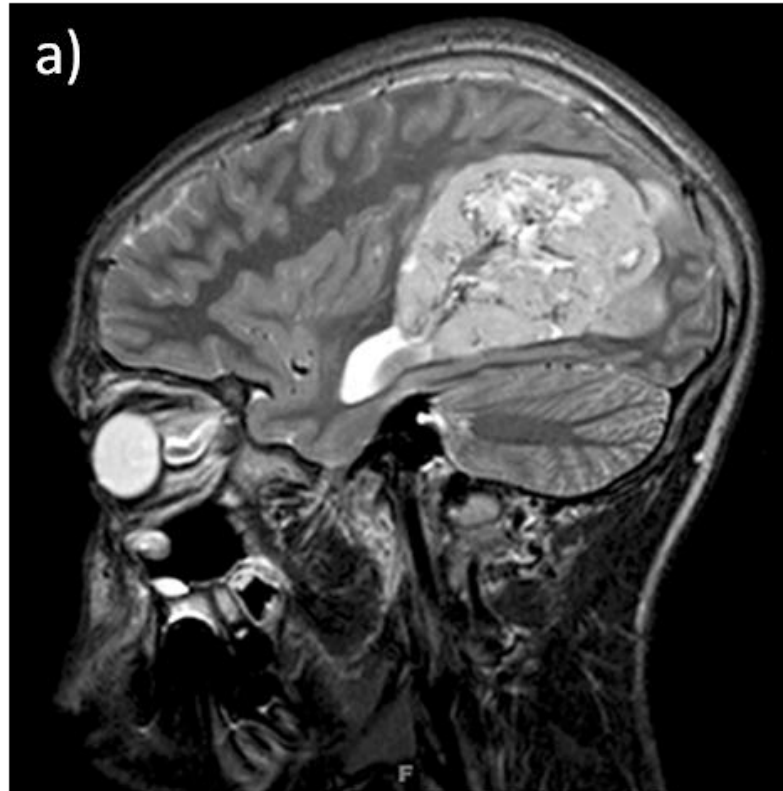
Sagittal section magnetic resonance images (MRI) of a supratentorial CNS-PNET. (a) T2-weighted image showing a large heterogenous cerebral mass, (b) areas of hypodensity on T1-weighted imaging suggestive of necrosis within the tumor. Figure adapted from (Behdad and Perry 2010).
